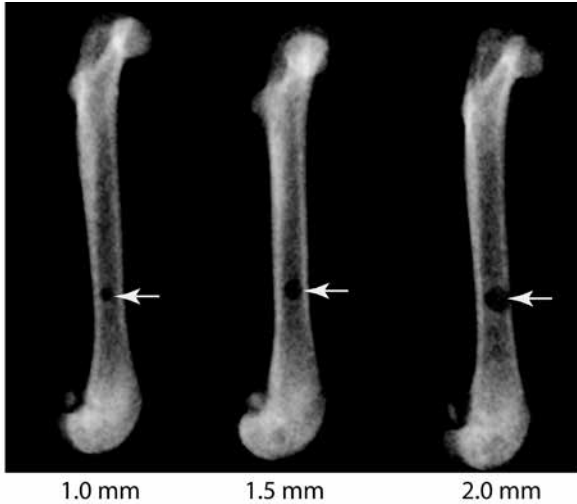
Radiographic representation of lesion sizes created by using a surgical bone drill prior to breaking of the femur. An arrow indicates each of the 3 lesions.
